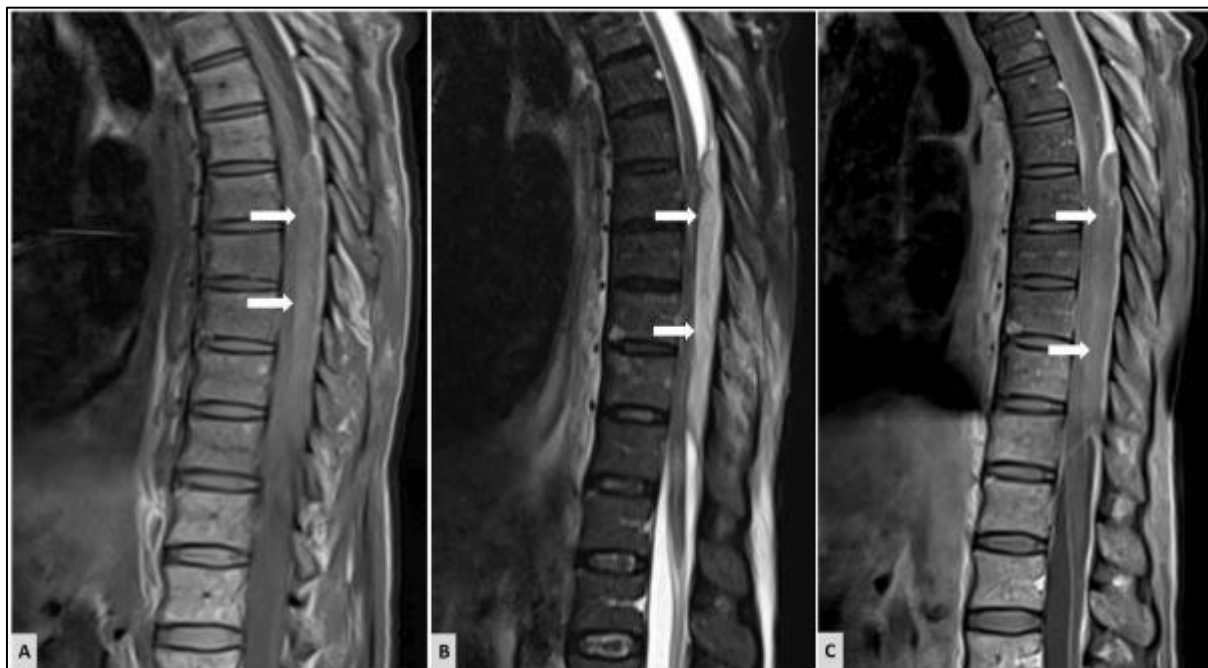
Sagittal magnetic resonance images: T1-weighted (A), T2-weighted (B), and post-contrast T1-weighted (C).
